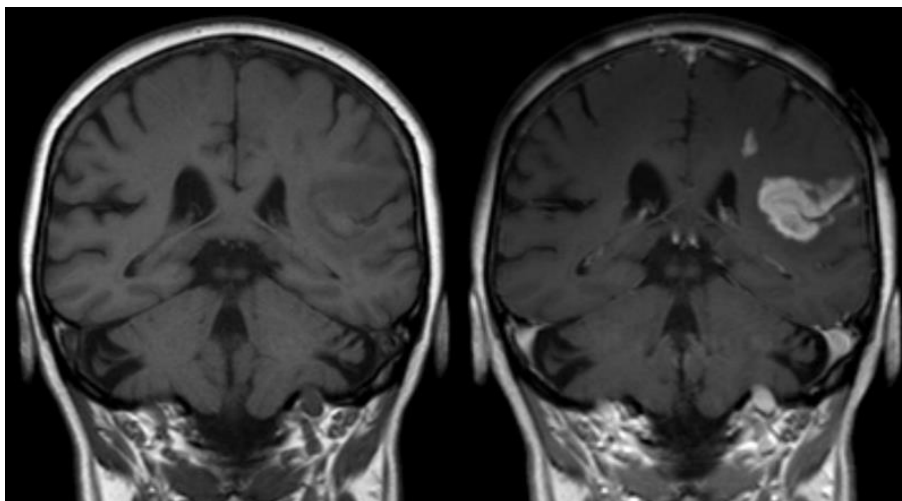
MRI image before and after the injection of MNPs
